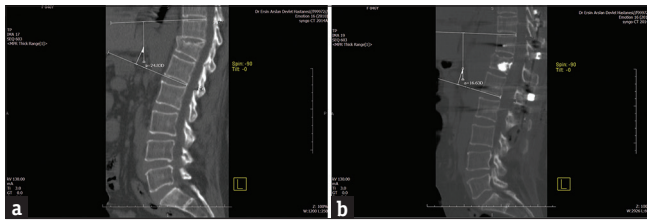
(a) Preoperative CT scan of a 46-year-old woman with a T12 fracture and posttraumatic T12 vertebral body wedging of 24.8°. (b) Postoperative CT scan of a patient showing the reduction of segmental kyphosis to 16.6°
